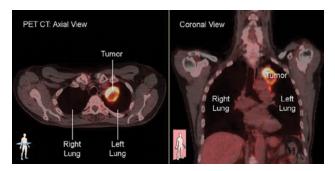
A combination of CT and PET may be useful for the radiotherapy planning of NSCLC if consolidation or collapse surrounds the primary tumor.
